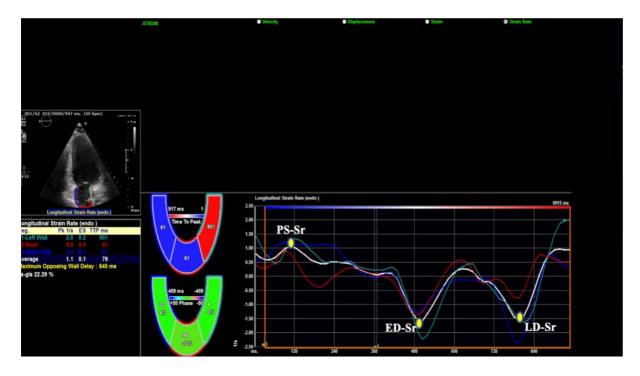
LA strain-rate using LV apical two-chamber view
